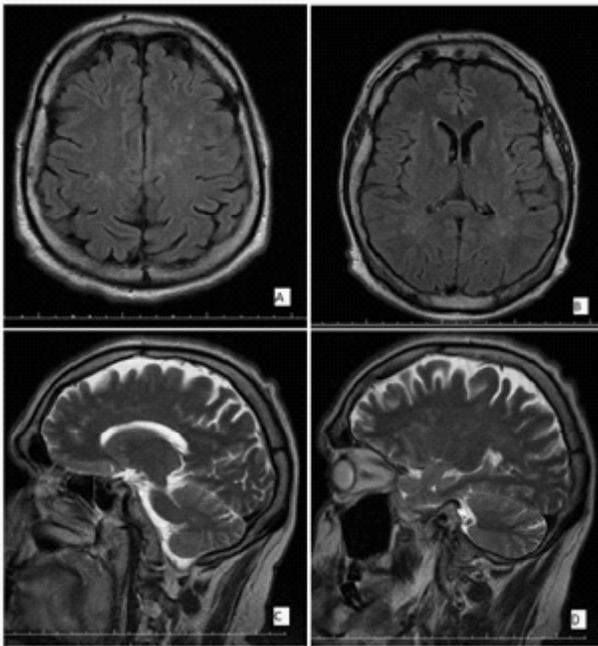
MRI of the CNS performed on the 9th of August 2017, after 40 weeks of antifungal treatment (T2-weighted images).
